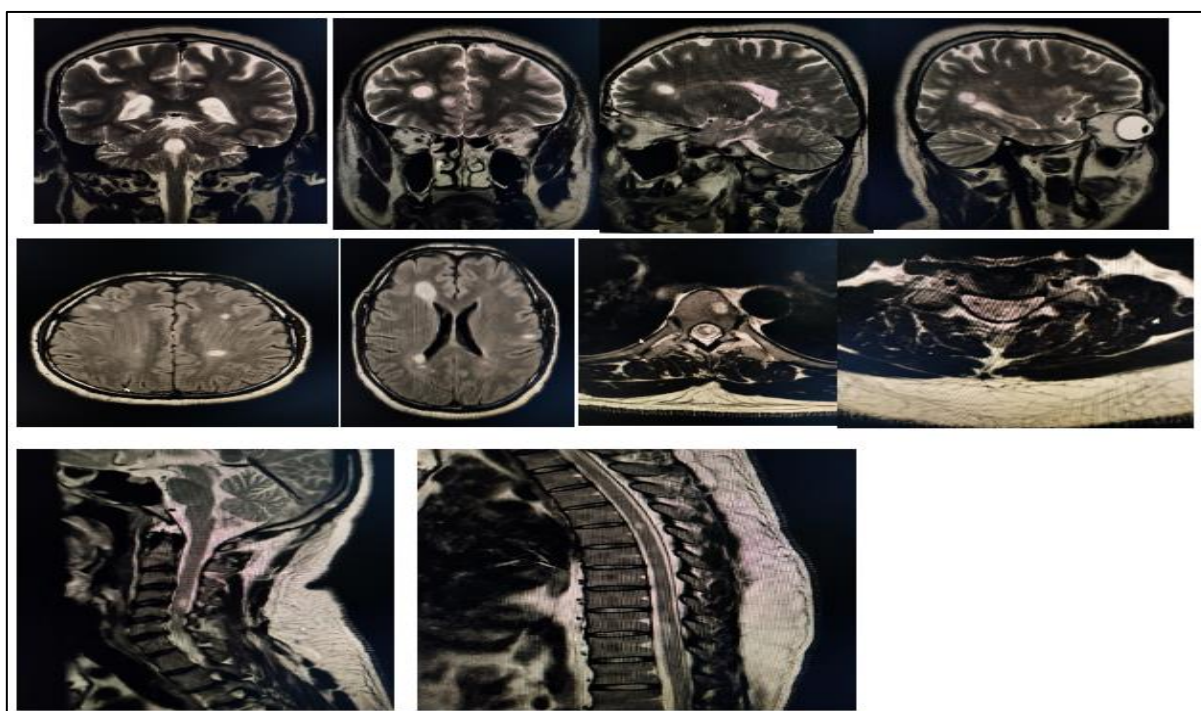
Magnetic Resonance Imaging (MRI) of Brain and Spine Showing Multiple Discrete Ovoid Lesions in the Juxtacortical Periventricular and Brainstem and Spinal Cord with Few Ovoid Block Spots in Periventricular Regions with Contrast Enhancement Suggestive of Active Lesions and Burnout Lesions Fitting Dissemination in Time and Space.
